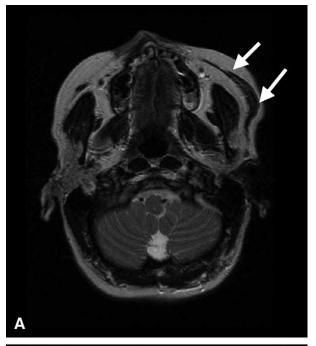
MRI appearance of microneurovascular muscle flap in a 38-year-old woman with congenital left-sided facial paralysis. Free muscle transfer with the gracilis was done 2 years before MRI. This flap has almost normal muscle structure (grade 1 in present study) and the patient's mimic function is good (mild dysfunction). (A) In an axial T2-weighted MR image and (B) in an oblique coronal T1-weighted MR image, the free muscle flap is indicated with a white arrow.
